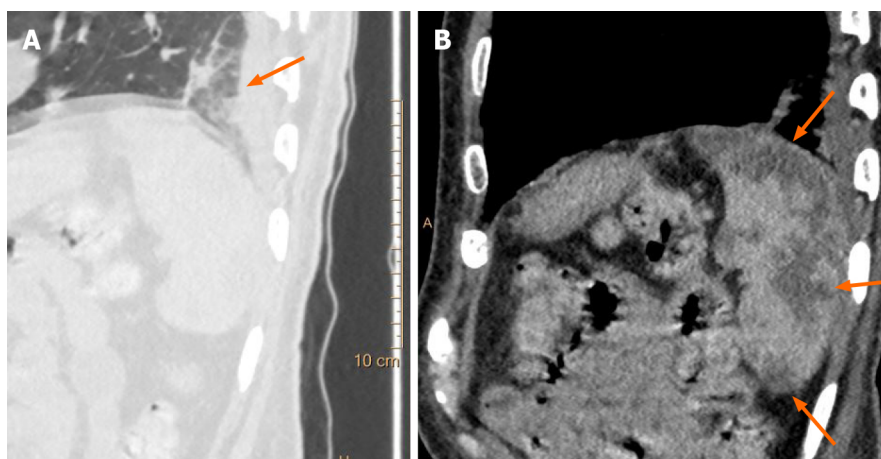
Incidentally detected splenic infarction in a patient with coronavirus disease 2019. A: Sagittal chest computed tomography (CT) image shows subpleural ground glass opacities in the lung fields in a case of coronavirus disease 2019 (orange arrow); B: Sagittal contrast enhanced CT image of the abdomen in the same patient show incidentally detected, sharply margined, wedge shaped, hypodense areas in the spleen, suggestive of splenic infarcts (orange arrows).
